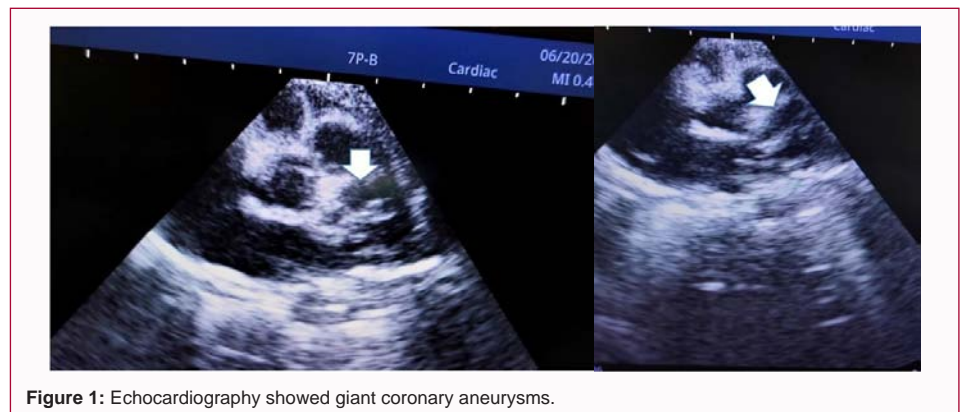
Echocardiography showed giant coronary aneurysms.
